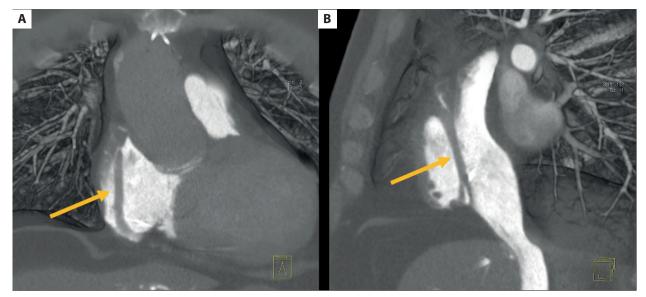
Cardiac computed tomography. Muscle bundle in the right atrium (yellow arrow): Coronal (A) and sagital (B) view
